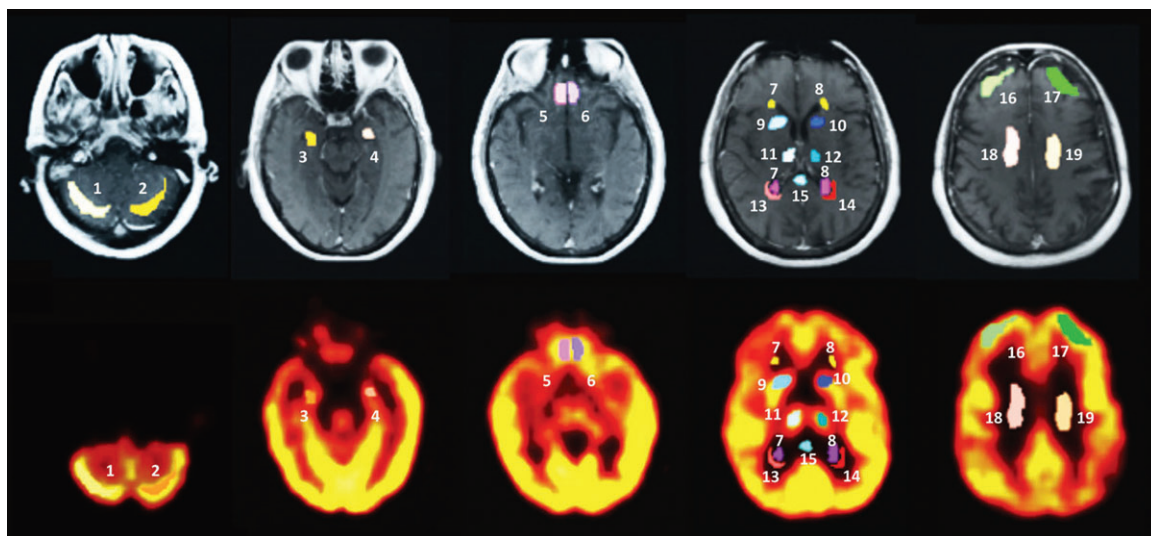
Regions of interest (ROI) placement on PET and corresponding magnetic resonance images. The figure shows an example of the ROI placement in gray and white matter regions and in germinal zones on magnetic resonance imaging (upper panel) and coregistration with corresponding PET scans (lower panel). From a total of 24 regions both SUV_{mean} and SUV_{max} were obtained. SUVs were analyzed longitudinally over time for each patient in all ROI, to include a pre- and postchemotherapy data set. (1,2): right and left cerebellar cortex; (3,4): right and left medial temporal lobe and hippocampus; (5,6): right and left orbitofrontal cortex/olfactory gyrus; (7,8): right and left anterior and posterior subventricular zone; (9,10): right and left caudate nucleus; (11,12): right and left thalamus; (13,14): right and left periventricular white matter; (15): corpus callosum (splenium); (16,17): right and left frontal cortex; (18,19): right and left subcortical white matter; Not shown in this representative image are: right and left parietal cortex, corpus callosum (genu), posterior cingulate, and cerebellar white matter. PET, positron emission tomography; SUV, standardized uptake value.
